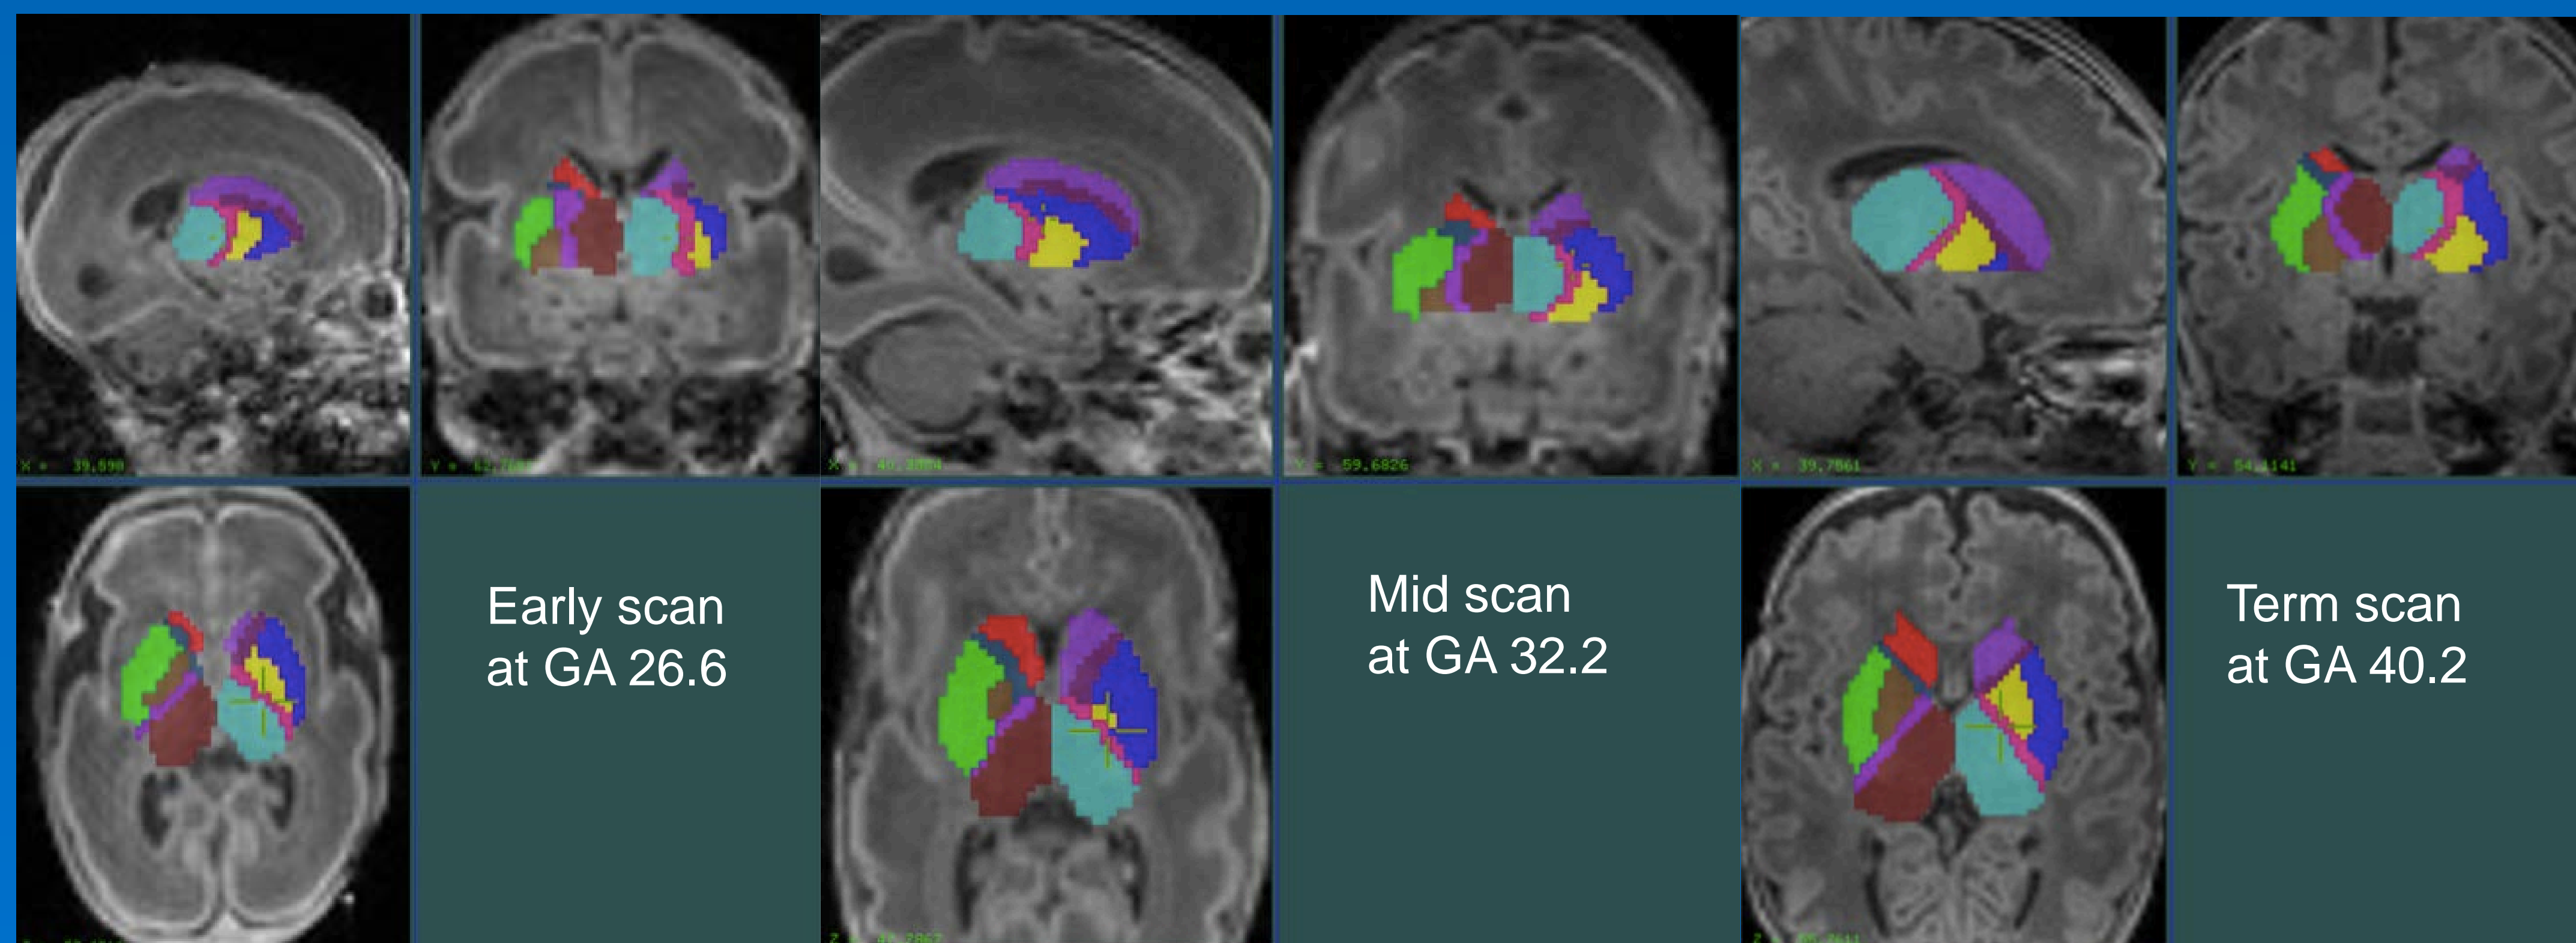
Segmentation templates on T1-weighted images from the same patient born at GA 27.3
